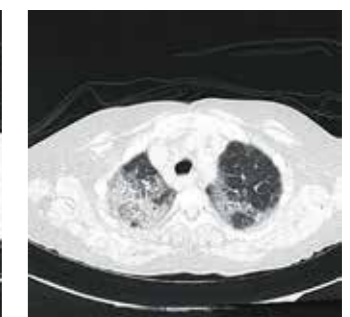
High-resolution computed tomography chest AQ8
